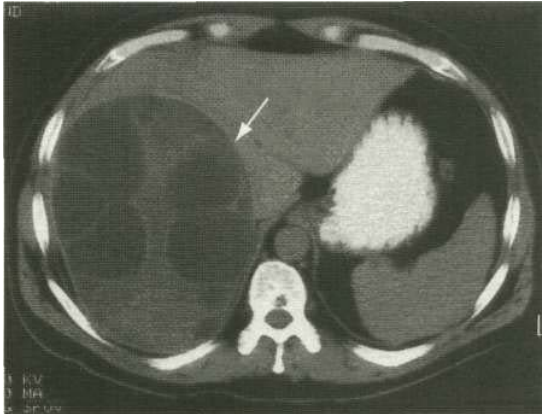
CT scan of liver showing a large hydatid cyst (arrow) with 'daughter' cysts lying within it.
